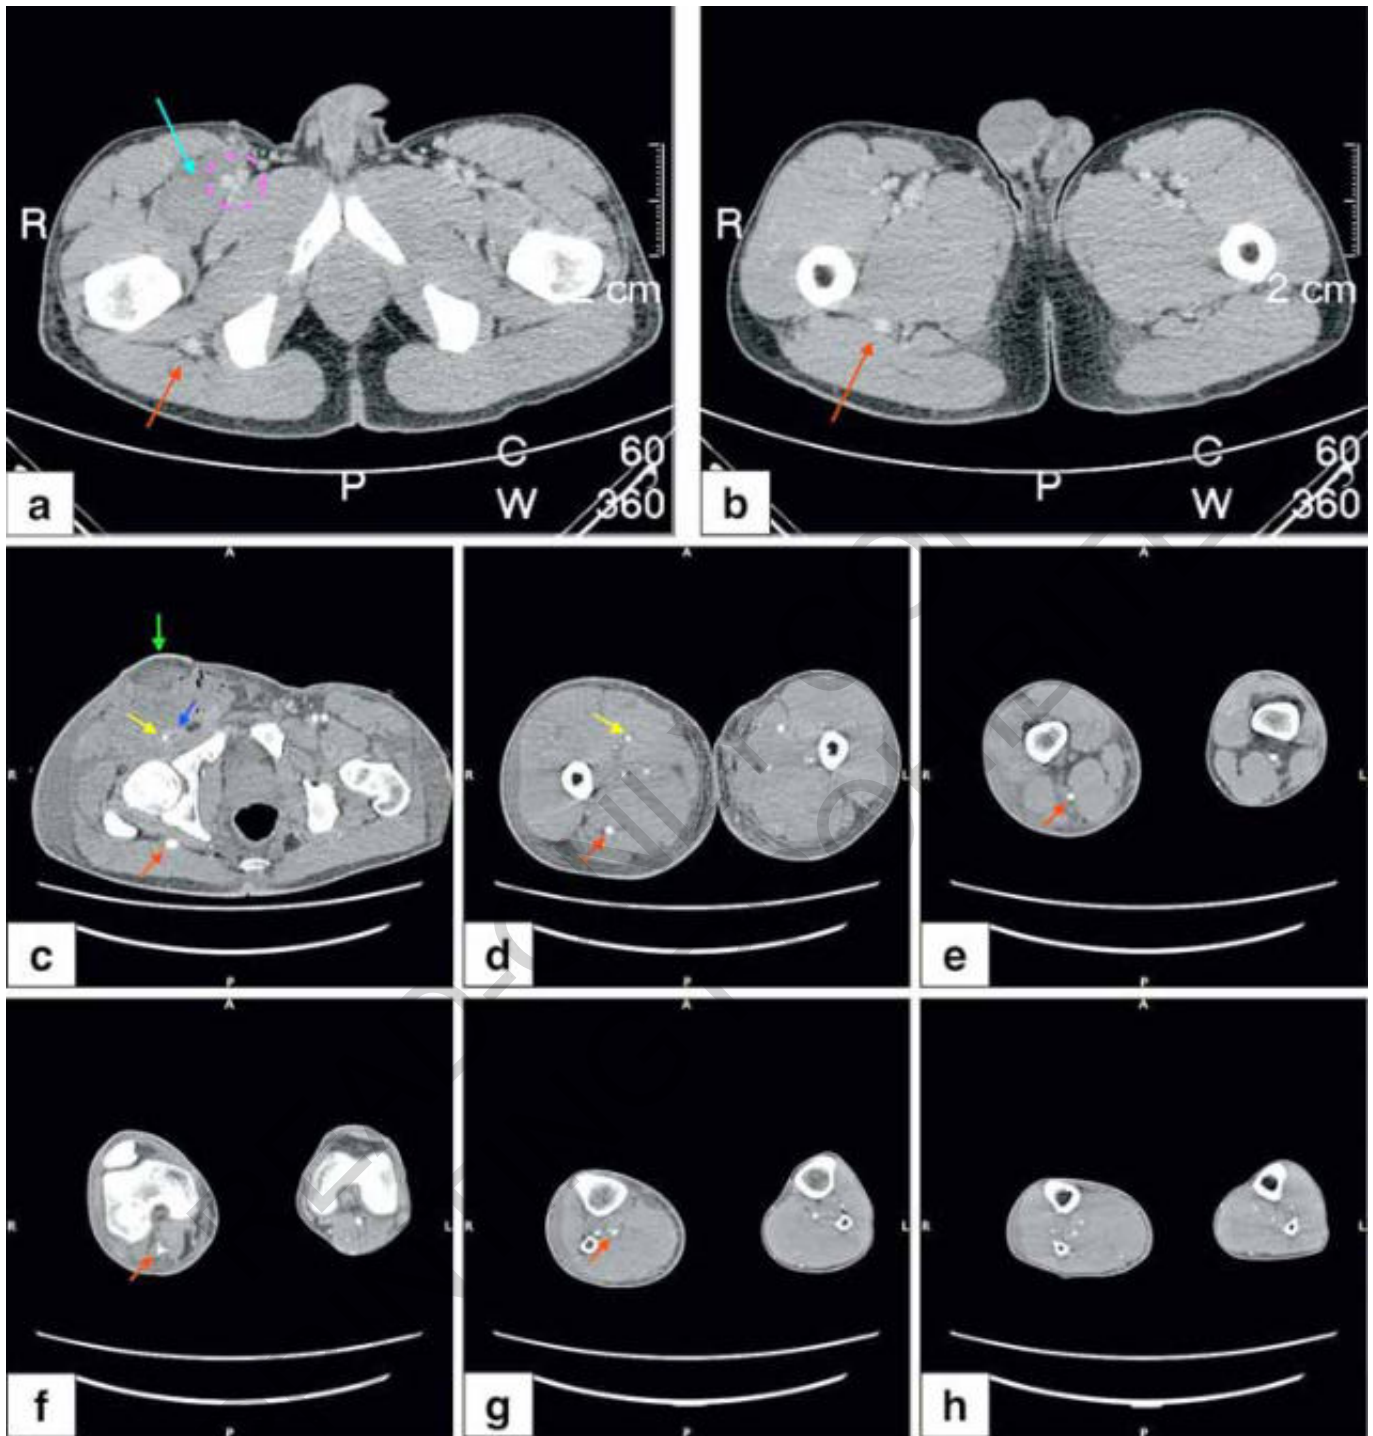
Preoperative CT scan (A, B) and postoperative CTA scan (C-H). Arrows and circle indicate main elements of the pictures (Red arrow: PSA; Yellow arrow: Native SFA and autologous arterial bypass; Blue arrow: occluded venous synthetic bypass; Cyan arrow: tumor burden; Green arrow: VRAM flap; Dashed circle: femoral neurovascular bundle).
